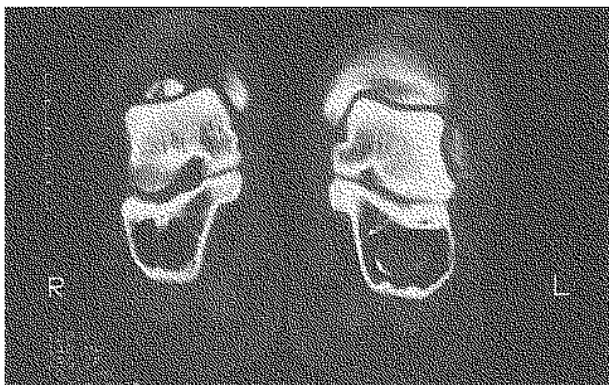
CT-scan of both calcanei showing osteolytic areas corresponding to intraosseous lipomas.
